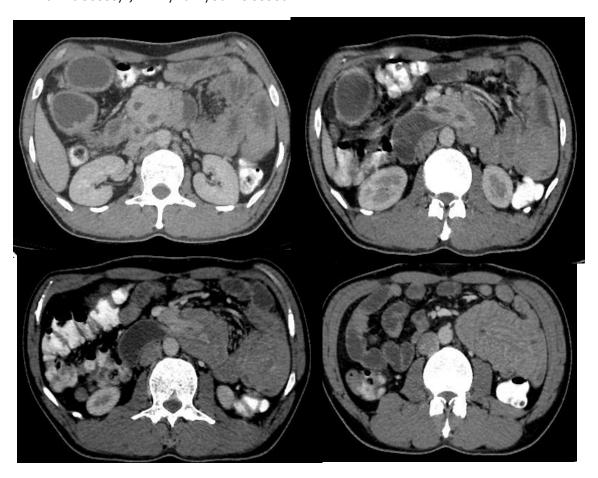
Axial contrast enhanced CT images taken at the level of upper abdomen (A to D) shows dilated MPD, CBD (black arrows) along with proximal duodenum and uncinate process of pancreas (white arrow) which is telescoping into distal duodenum (white arrowhead) forming a sausage shaped mass (white arrow heads) in left hypochondrium.
